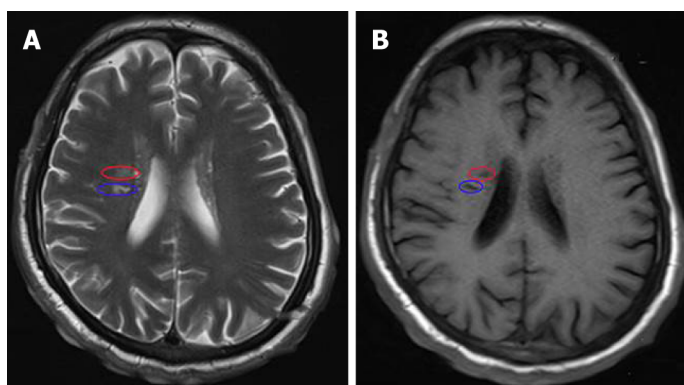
Magnetic resonance imaging revealing abnormal hyperintense lesions in the bilateral insular cortex and radial crown, and lateral anterior horn. The circles in blue and in red indicate lesions. A: T2 weighted imaging; B: T1 weighted imaging.
